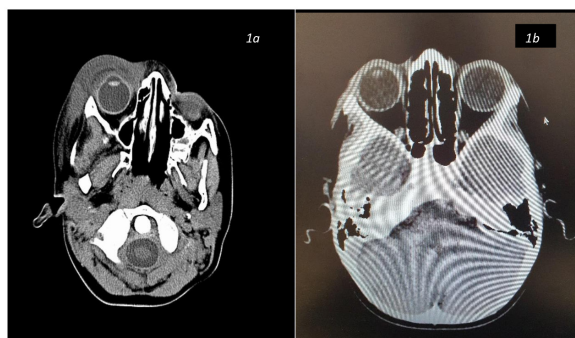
Preoperative CT, dense inflammation and thickening of the eyelid and periorbital area on CT.
